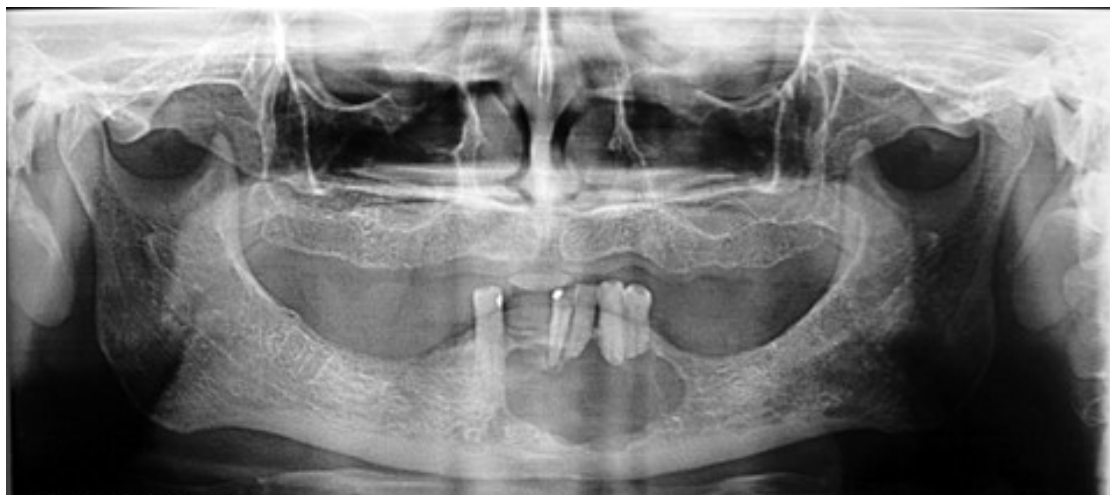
Panoramic radiograph. Note large circumscribed radiolucent image extending from the sagittal midline and resorption in the roots of the teeth 3.3 and 3.4.
